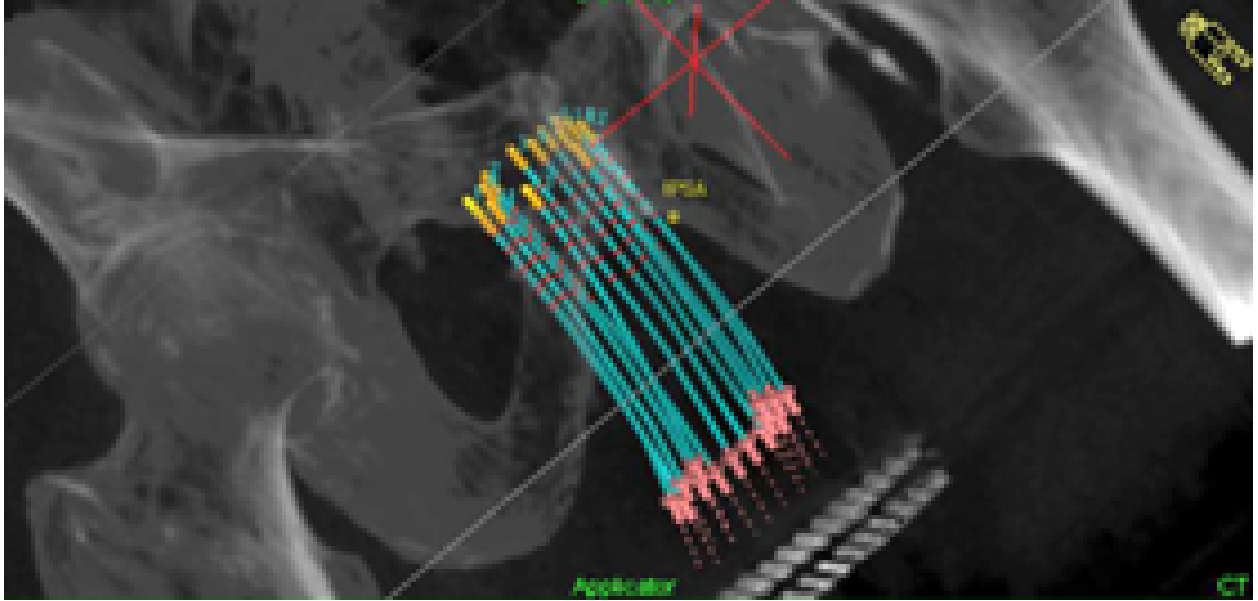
Needle reconstruction on CT image for HDR prostate brachytherapy.
